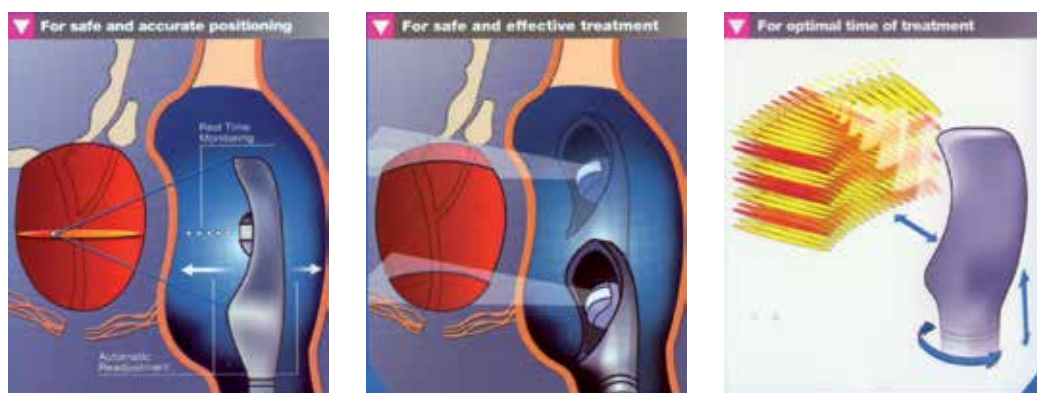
HIFU mechanism scheme. On the left, ultrasound beam positioning; in the middle, the area to treat; on the right, an overall view of the sections treated by high-intensity ultrasound.
